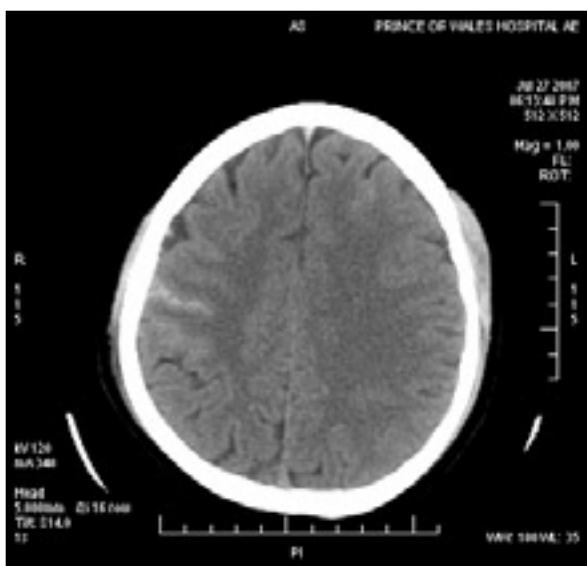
Computed tomography of the brain showing the convexity subarachnoid haemorrhage
